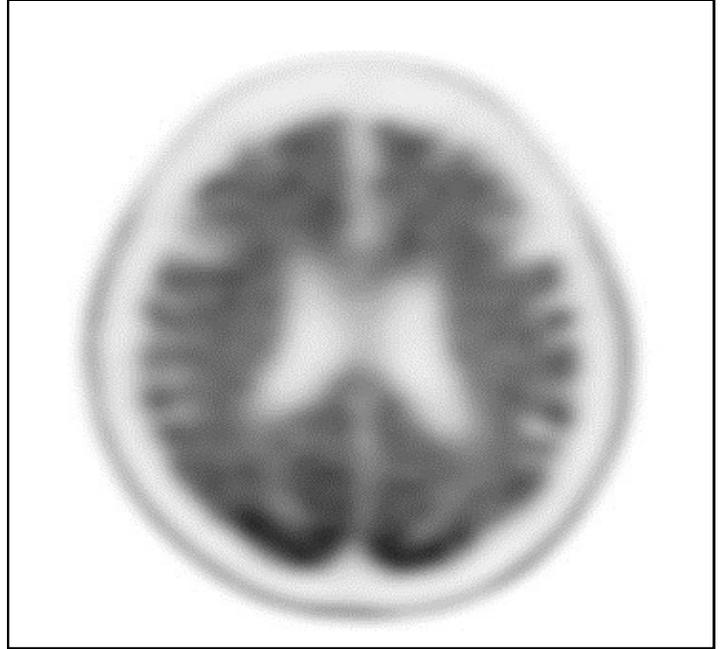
Positive Amyloid Scan. This PET/CT scan is positive for significant amyloid in the brain. The radiopharmaceutical (black) accumulates in both the white and gray matter, with distribution out to the periphery of the brain. This scan is consistent with Alzheimer’s disease.
